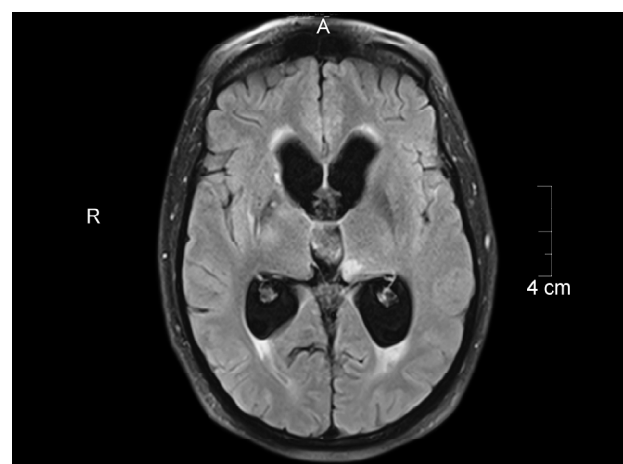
MRI brain axial flair T2W image showing enlarged third and lateral ventricles in a patient of TBM
